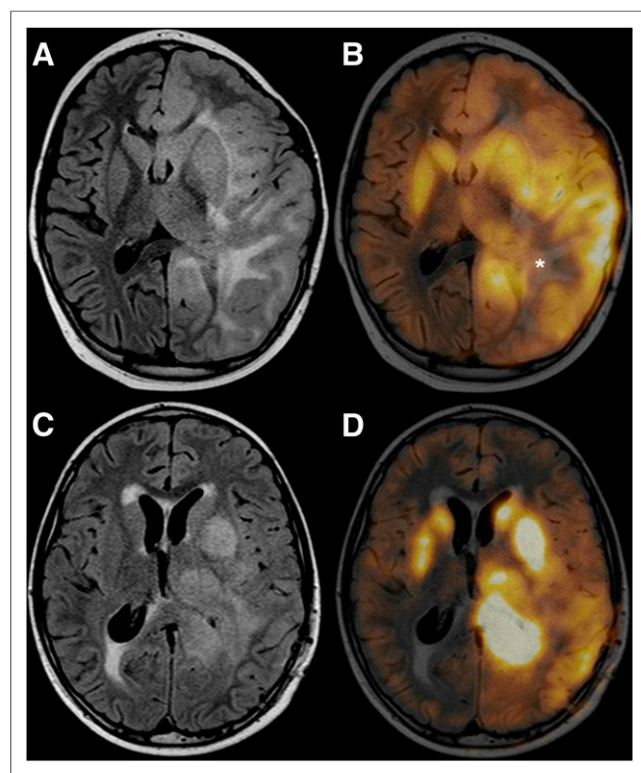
(A and B) GC (WHO grade II) (case 10). Extensive left hemispheric lesion with ipsilateral involvement of basal ganglia and thalamus (FLAIR image, A). ^{18}F -DOPA PET/MR imaging fusion (B) shows areas of moderately to markedly increased tracer uptake (T/N, 2.3; T/S, 1.2) concordant with tumor extent. Notice absence of tracer uptake within areas suggestive of vasogenic edema (*, B). Biopsy sample performed before PET presumably undergraded lesion. (C and D) GC (WHO grade IV) (case 13). ^{18}F -DOPA PET MR imaging fusion (D) shows areas of moderately to markedly increased tracer uptake (T/N, 2.3; T/S, 1.4) in left hemisphere extending beyond FLAIR tumor extent (C).
